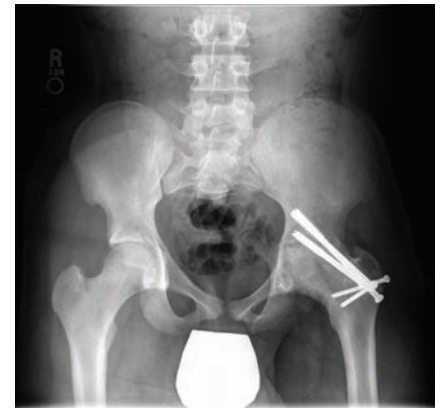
X-ray out of plaster at six weeks post-op following trans-articular hip arthrodesis via trochanteric flip osteotomy with open surgical dislocation of the hip.
